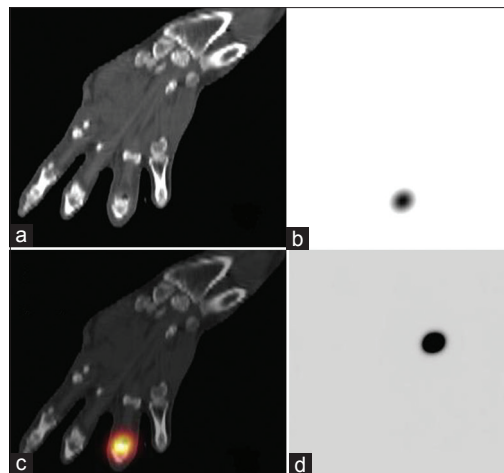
Coronal computed tomography (a), single-photon emission computerized tomography (b), fused single-photon emission computerized tomography/computed tomography (c) and maximum intensity projection image (d) rhenium-188 tin colloid images of hand showing good tracer distribution in the right 4th proximal interphalangeal joint
